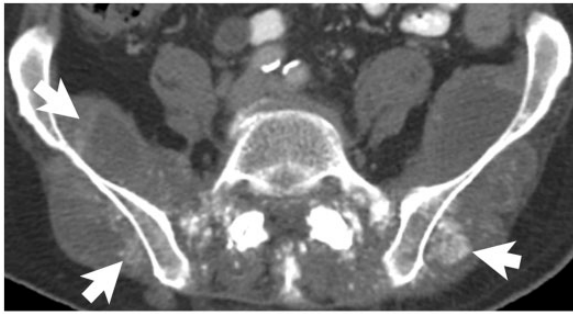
A 77-year-old man with rectal adenocarcinoma, without mucinous differentiation. Axial noncontrast CT image demonstrates prominent calcification (arrows) in the metastases within the gluteal and paraspinal muscles. These developed while the patient was on chemotherapy.
